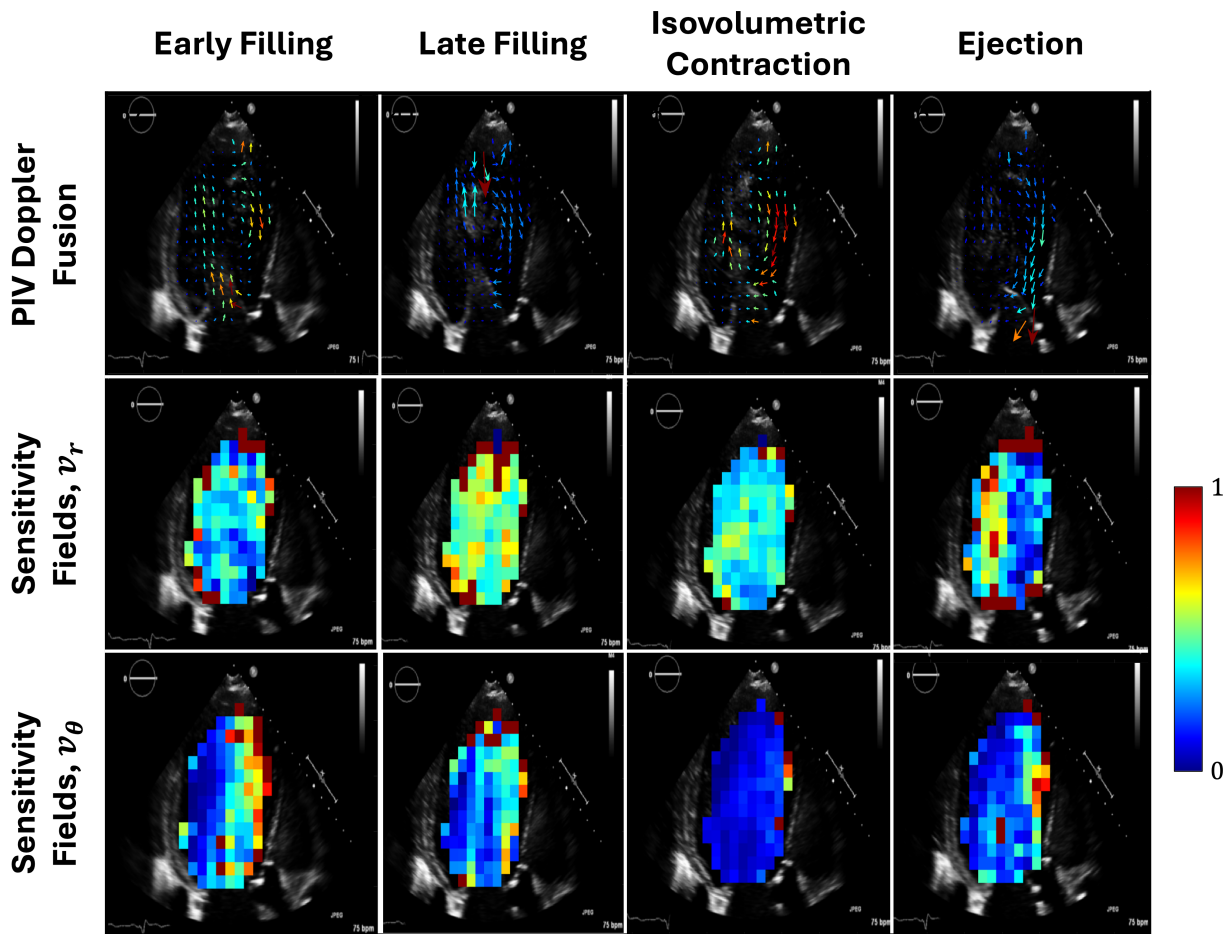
PIV–Doppler Fusion Sensitivity Maps (normalized). Row 1 shows the PIV Doppler fused velocity fields. Rows 2 and 3 present local sensitivity estimates in the radial and azimuthal directions. Higher local sensitivity appears near boundaries, due to input segmentation uncertainty, and within the inlet jet, where qualitative discrepancies between PIV and Doppler inputs are more pronounced.
